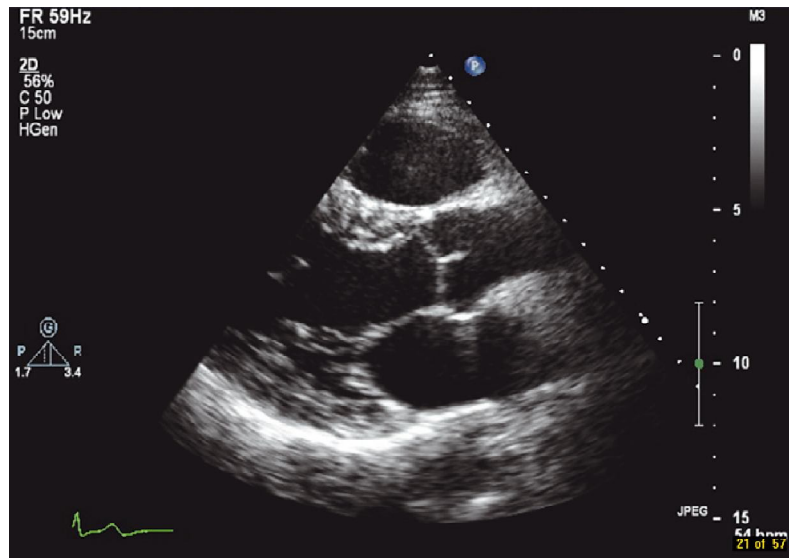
shows normal parasternal long axis view(Houghton, 2013).
